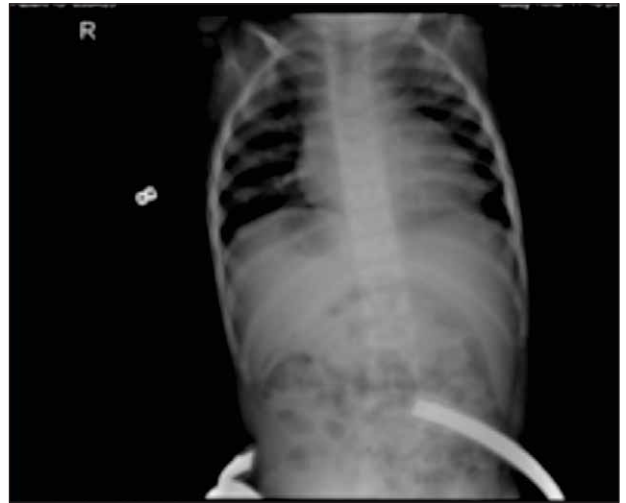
Chest X-ray check-up
